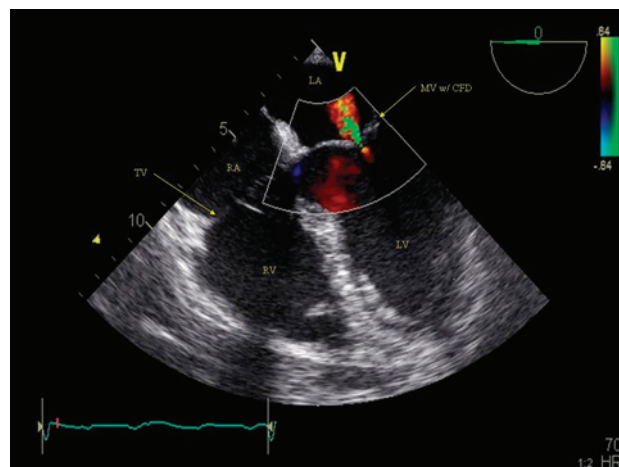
Mid-esophageal 4-chamber view with colorflow Doppler over the mitral valve.
